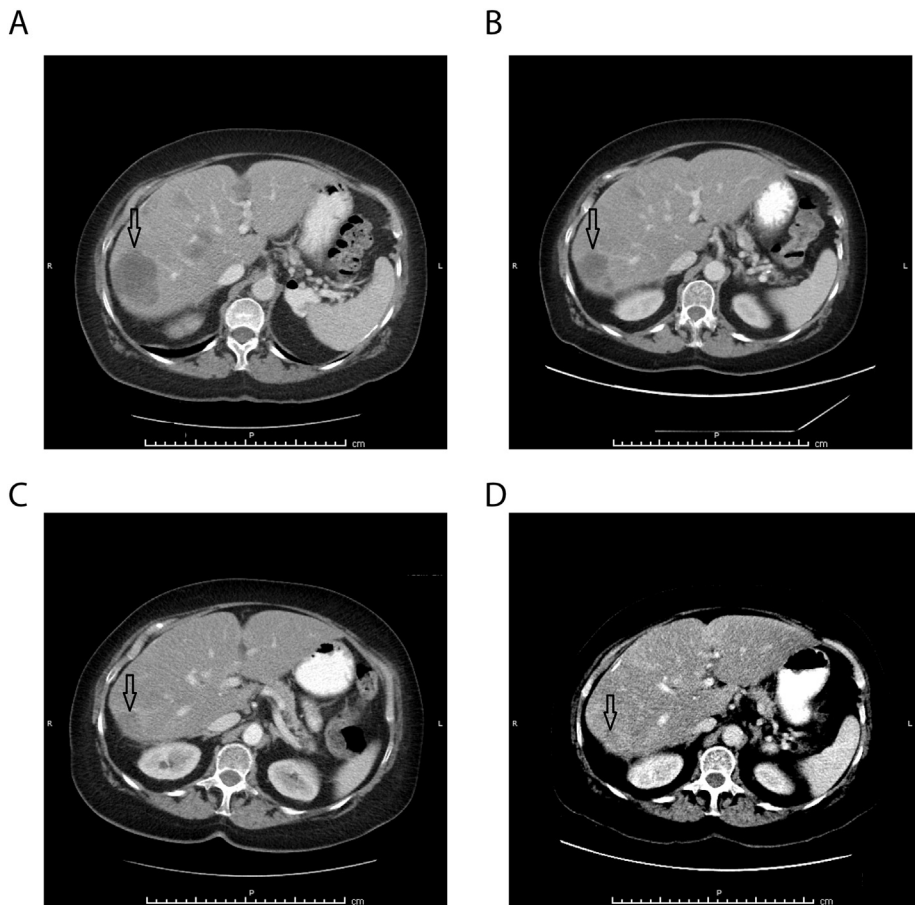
Representative CT scans demonstrating activity of IMMU-132.
